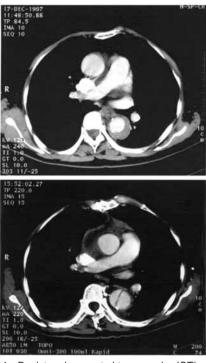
Registered computed tomography (CT) of No. 5 patient of Table 1: Upper, the false lumen was thrombosed at hospitalization. Lower, there were the retrograde extension of aortic dissection at 64 days.
